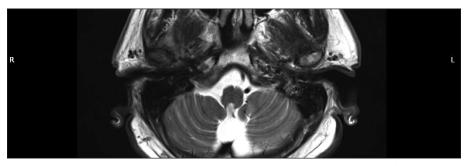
Postoperative MRI in patient B, T2-weighted sequence, axial view, upon follow-up (five years after treatment) without a cholesteatoma mass in the left external auditory canal.
